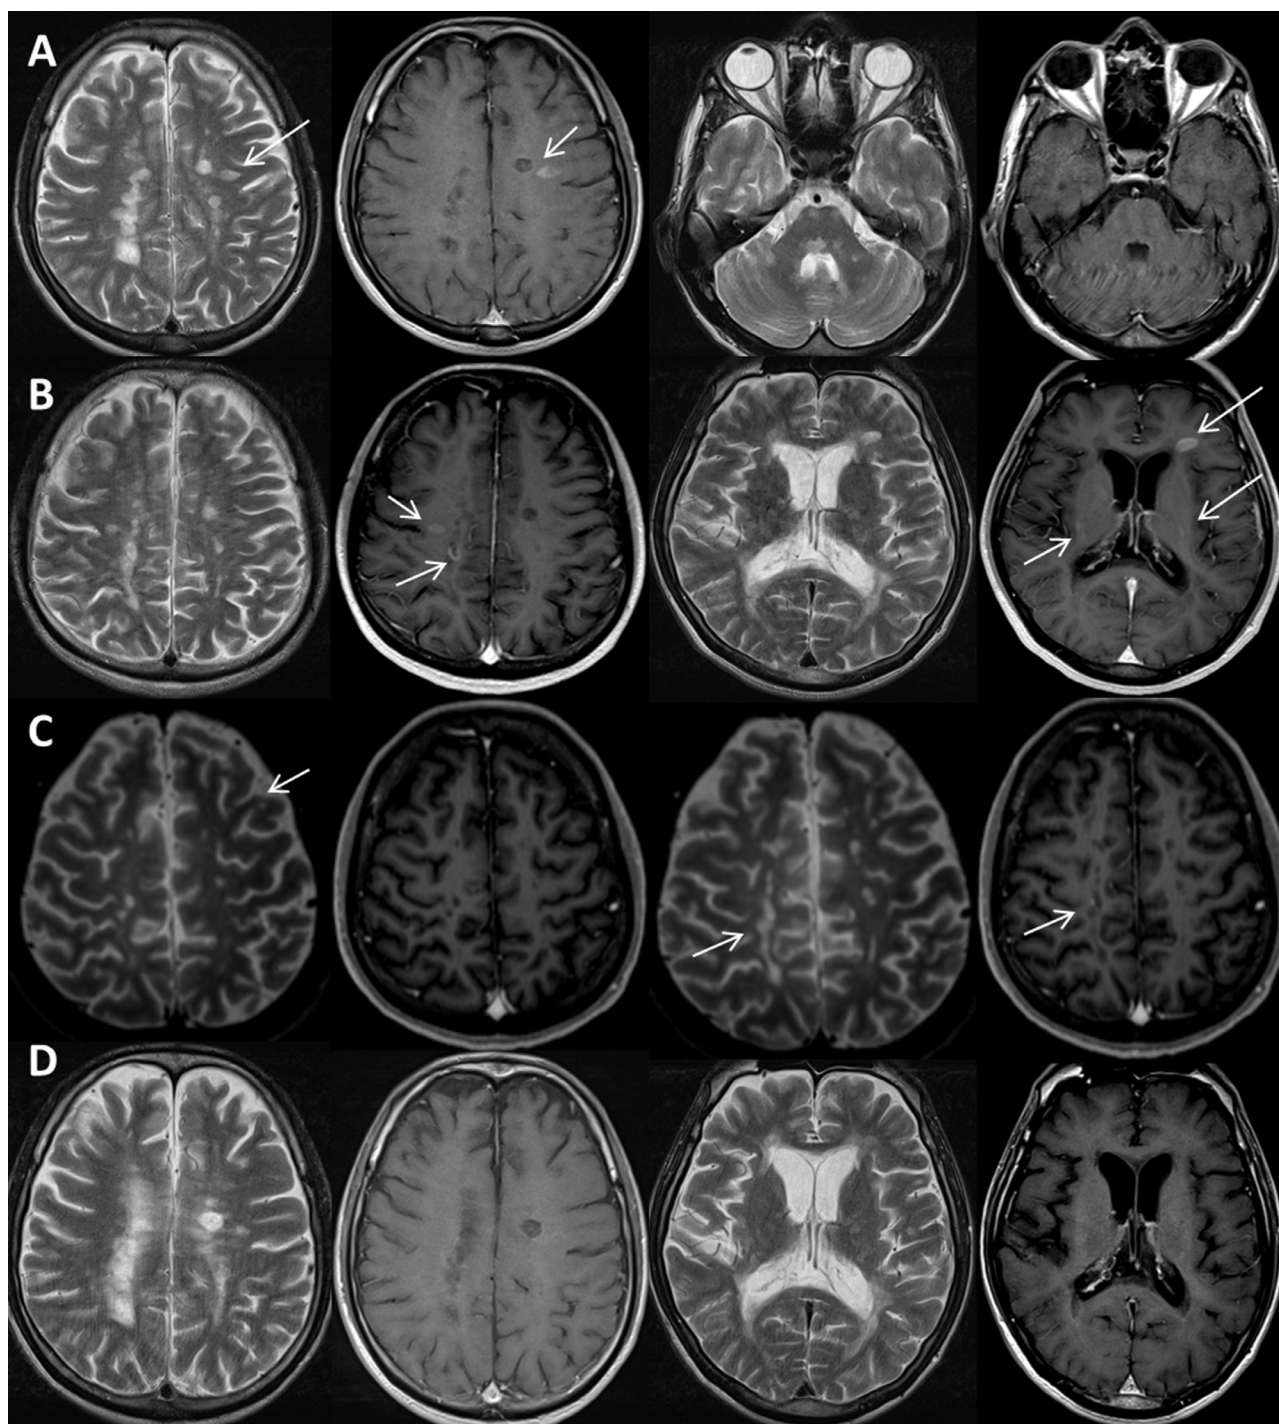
Axial T₂ and post contrast T₁ weighted MRI 18 months before treatment (A), at baseline (B), 12 months after the first (C), and five months after the second cladribine treatment cycle (D). Arrows indicate areas of gadolinium enhancement.
